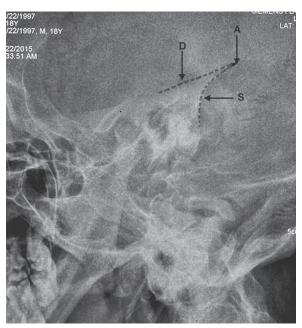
X-ray mastoid—well pneumatized mastoid
